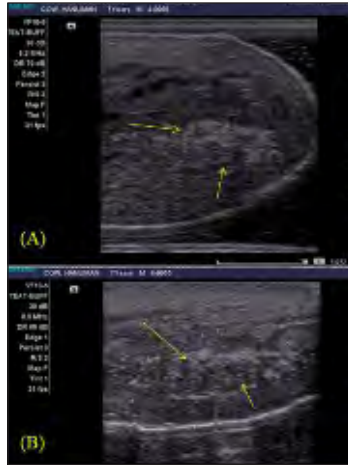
(A, B). Ultrasonographic image of healed region of teat fistula on 15th day observation show more hyperechoic pattern at healed region marked by arrow. (Water bath technique; vertical scan; 8MHz linear probe)
